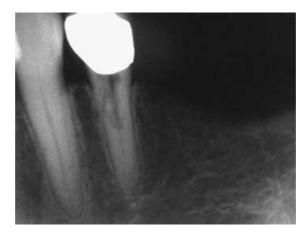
Diagnostic radiograph at the beginning of treatment showing an irregular translucency superimposed on the root canal.
